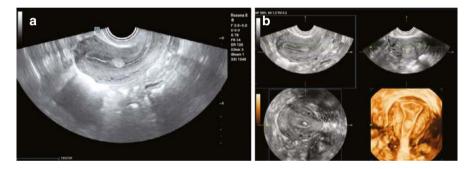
(a) On 2D ultrasound, an endometrial polyp demonstrates a well-defined, teardrop-shaped hyperechoic mass. (b) A 3D coronal view shows an endometrial polyp
